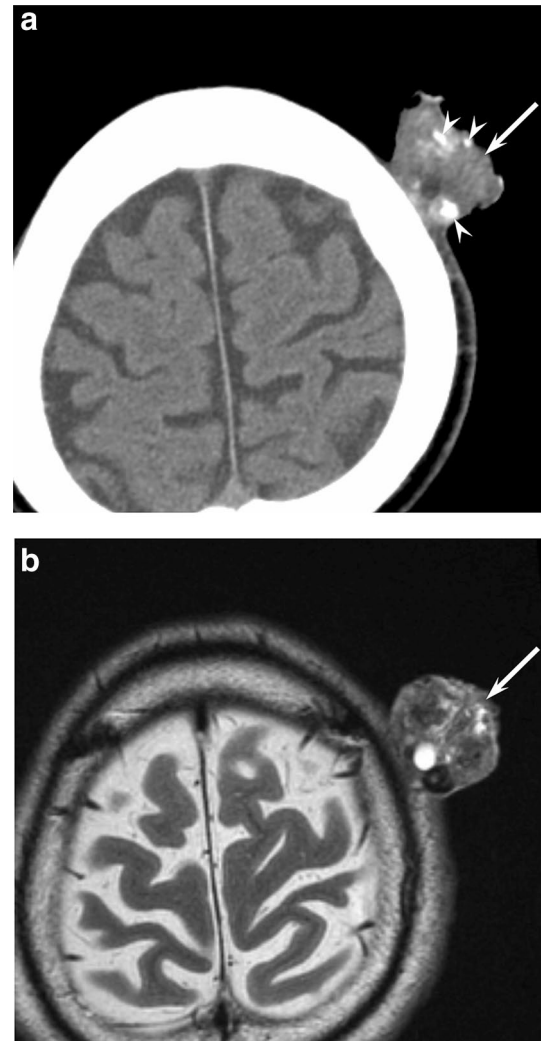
A 62-year-old man with proliferating trichilemmal tumor. a. Unenhanced CT image shows an irregular-shaped lesion (arrow) with calcification (arrow heads). b. T2-weighted image shows heterogeneously low to high signal intensity (arrow)
